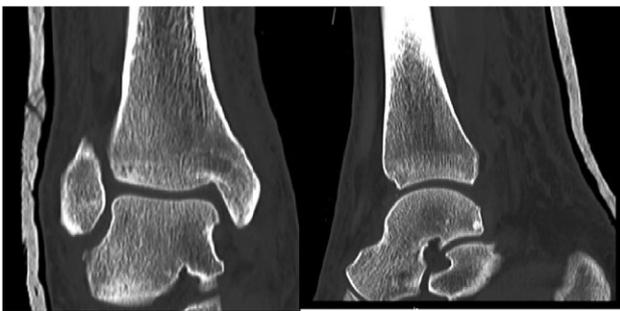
Post reduction CT scan showing congruent reduction of the dislocation without associated fractures.
